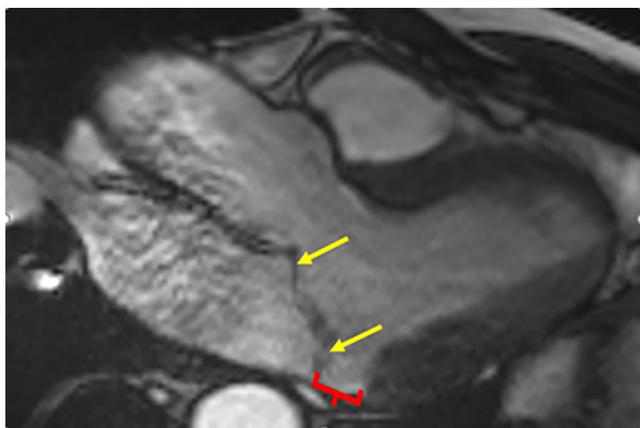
Mitral annular disjunction (red bracket) associated with bileaflet mitral valve prolapse (yellow arrows) on cardiac magnetic resonance imaging in Case 1.
